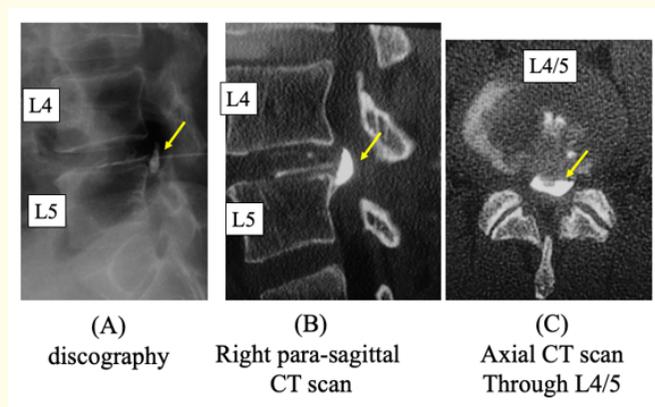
Findings on discography and CT before surgery. (A) A discogram shows that the contrast medium injected into the herniated nucleus pulposus has migrated into the fragment (yellow arrow), strongly suggesting a discal cyst. (B, C) The findings are the same in (B) a right parasagittal CT scan and (C) an axial CT scan through L4/5. CT, computed tomography.
